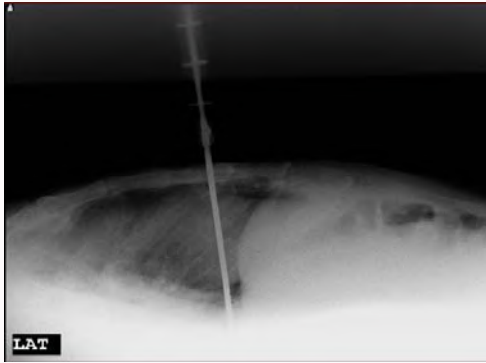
Lateral chest radiograph. A knife, penetrating into the left hemithorax is demonstrated.
